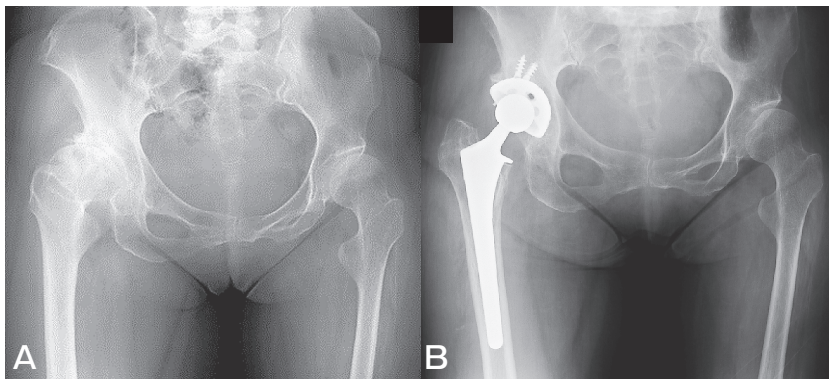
Representative non paralytic-side THA case (Patient 3). A, Preoperative AP radiograph; B, Postoperative (4.5 years) AP radiograph.
